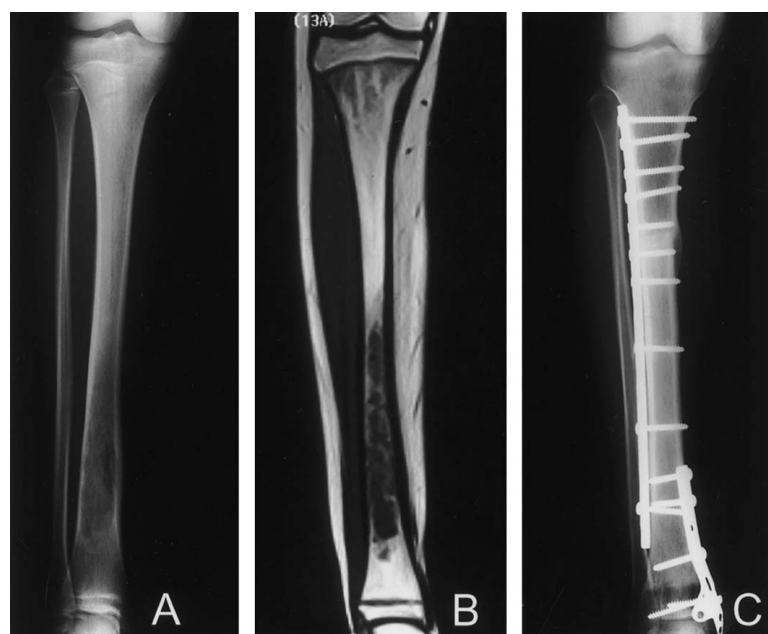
Two-plate fixation in a metadiaphyseal distal tibia intercalary allograft is shown in a 13-year-old-girl who had resection of an osteosarcoma. (A) An AP radiograph shows a lytic lesion without cortical disruption. (B) A T1-weighted coronal MRI scan shows the bone lesion extension in the distal tibia without soft tissue extension. (C) An AP radiograph taken 3 years after reconstruction shows the host-graft unions with mature callus, and preservation of the distal epiphysis.
